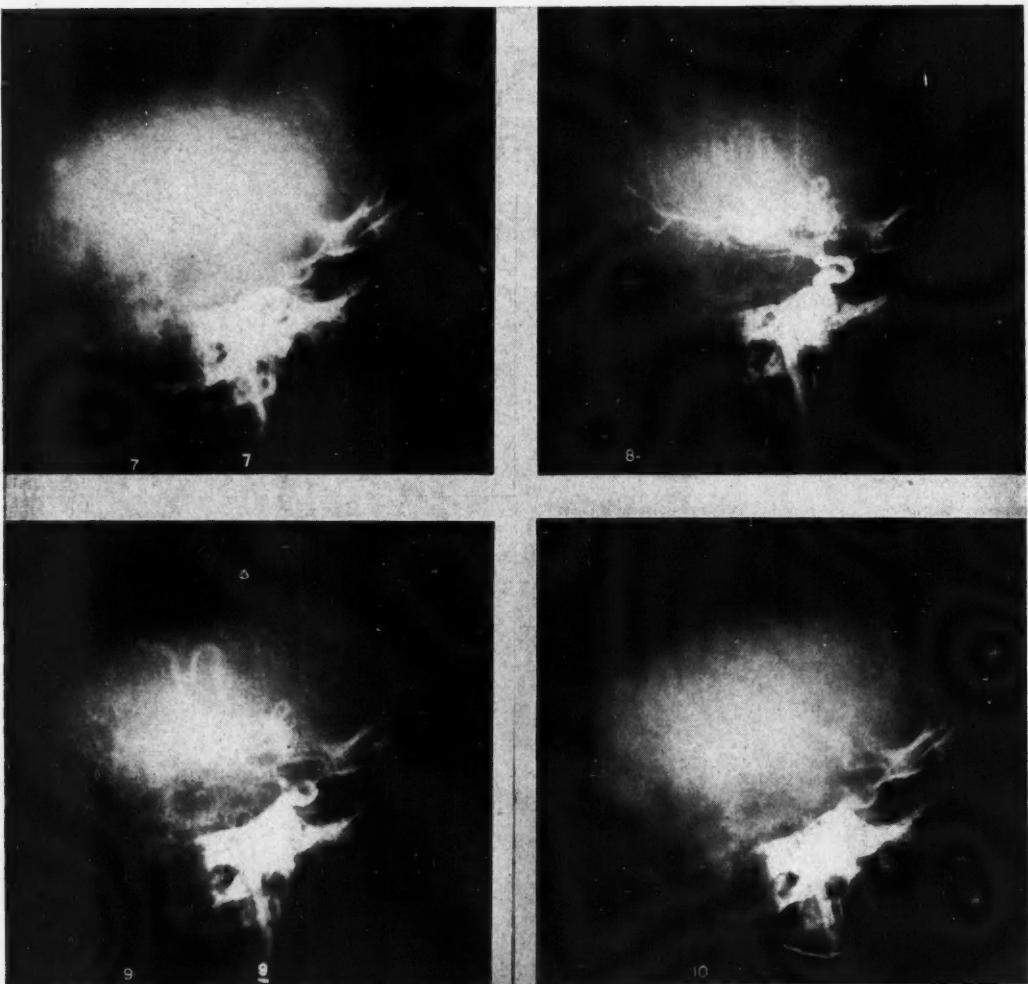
Serial cerebral angiogram (interval between roentgenograms $\frac{3}{4}$ second) on a 32-year-old woman. Ten cc. of 35 per cent Diodrast was injected into the right common carotid. A vascular tumor is demonstrated in the right upper temporal area. If rapid roentgenograms are taken, small quantities of opaque media may be used and good diagnostic visualization obtained.
